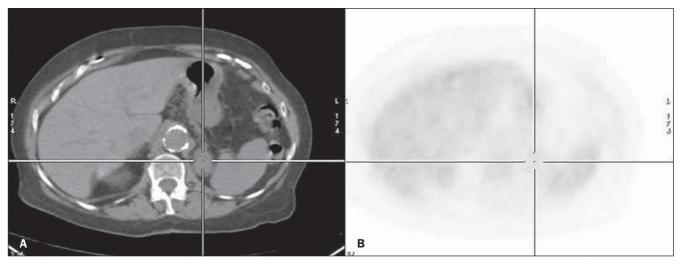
Male patient, smoker, at initial NSCLC staging. At CS, patient presented inoperable disease. Probable left adrenal metastasis at CT (A: axial section), however without increase in metabolism (B: axial section). Follow-up studies did not demonstrated any change in the left adrenal gland.
